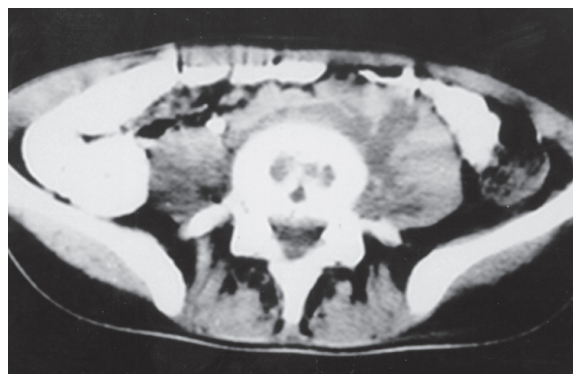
A contrast enhanced CT scan of the lower spine shows vertebral destruction and contrast enhancing paravertebral abscess with extension in the epidural space and psoas muscle.
